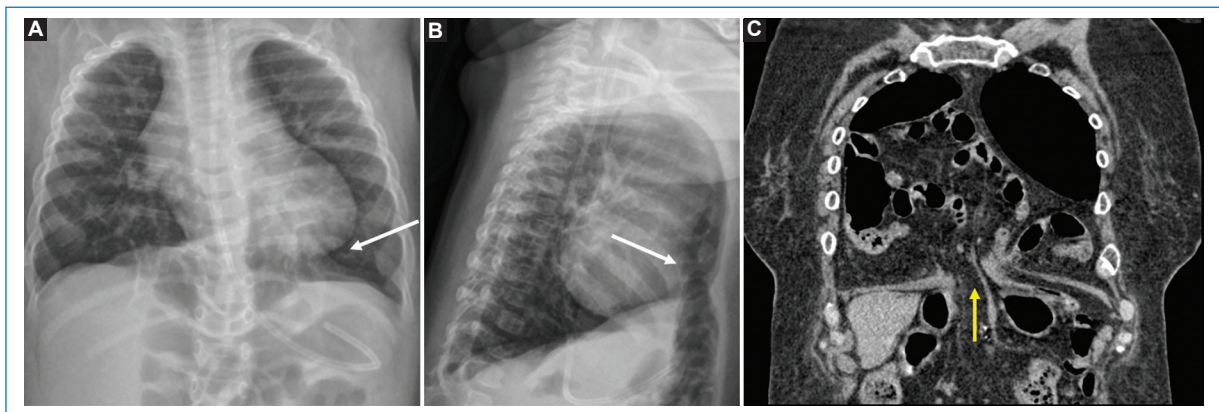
Morgagni hernia. Frontal (A) and lateral (B) chest X-ray, showing a retrosternal diaphragmatic defect with midline hydro-air images in continuity with the intra-abdominal intestinal loops (white arrows). Coronal reconstruction (C) of multidetector computed tomography of the chest showing an anterior diaphragmatic defect with ascent of intestinal loops and adipose tissue (yellow arrow).
